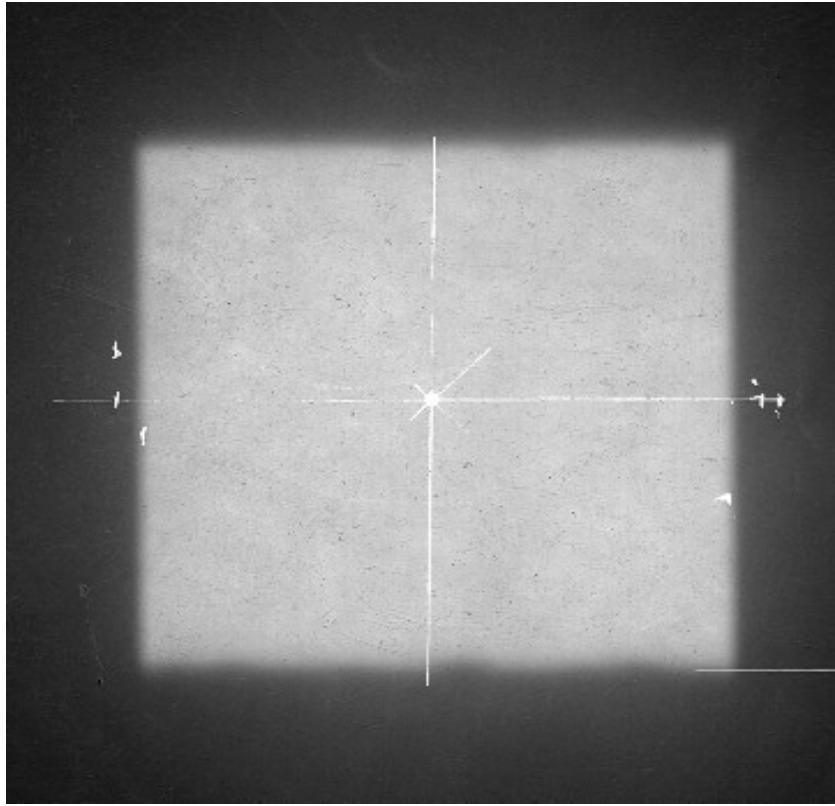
radiographic image with linear accelerator, measured field size was 10×10
